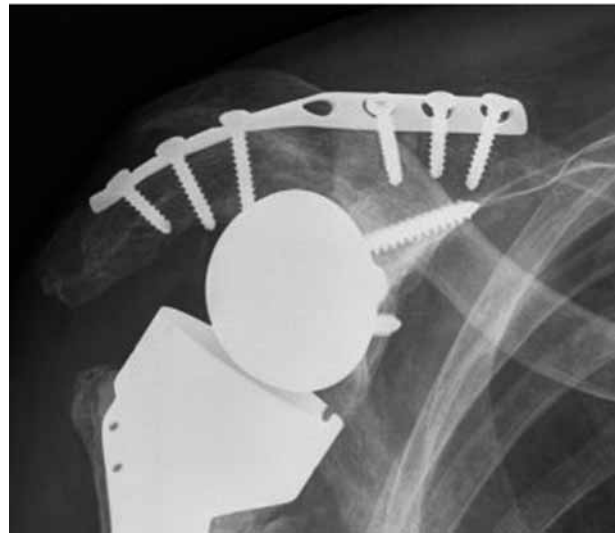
Standard radiograph of the right shoulder after internal fixation of the fracture.
